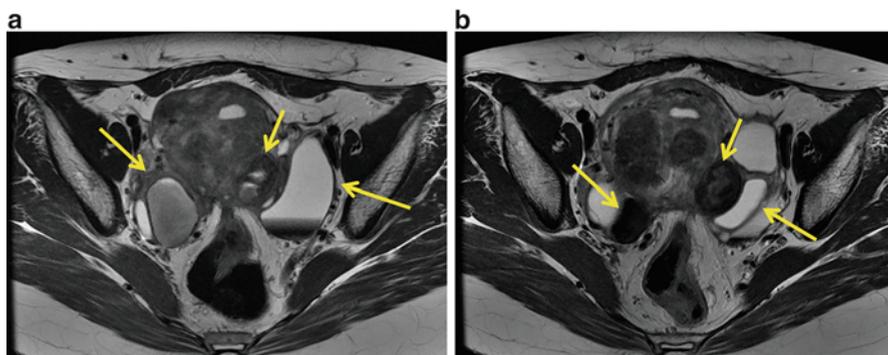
A 34-year-old woman with bilateral ovarian endometriotic cysts. Bilateral endometriotic cysts (*arrows*) show hyperintensity with subtle shading on axial T2-weighted images obtained before hormone therapy (a). The size and signal intensity of the cysts (*arrows*) decreased after hormone therapy (b)
